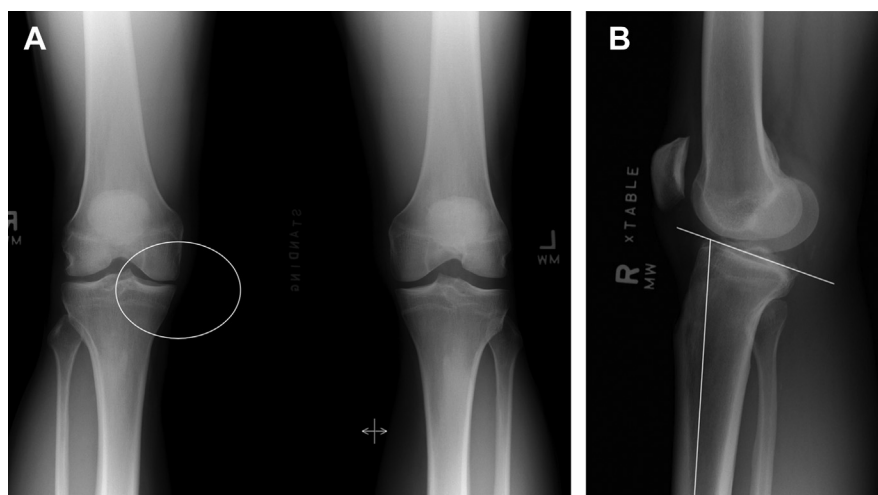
Patient with symptoms of knee instability and examination findings of ACL laxity, lateral gapping, and varus thrust during gait. Anteroposterior (AP) (A) and lateral (B) radiographs show varus alignment (circle in A) with an increased posterior tibial slope (B).
